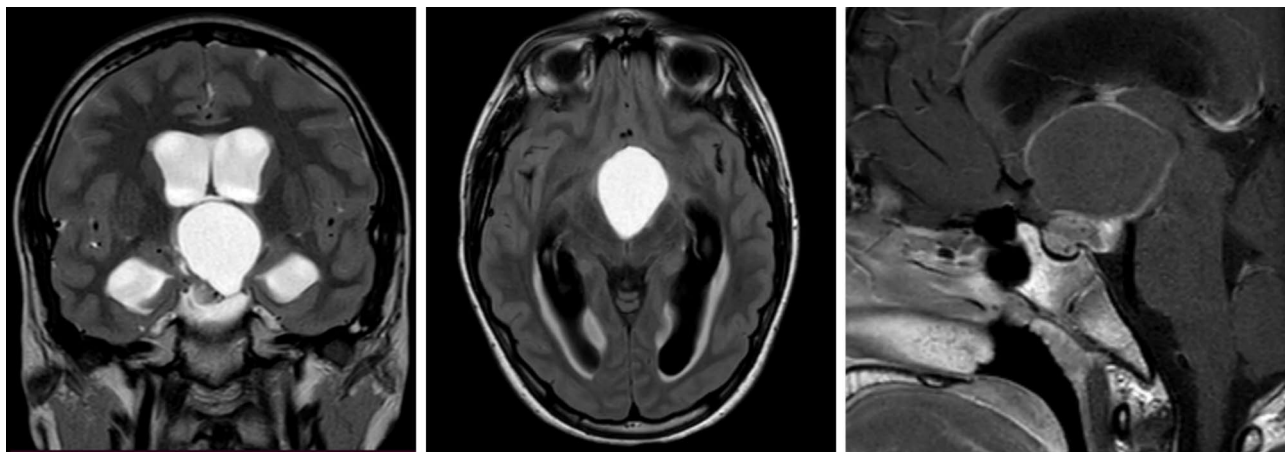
Baseline MRI of a 14-year-old patient diagnosed with a cystic, adamantinomatous craniopharyngioma with hypothalamic involvement
